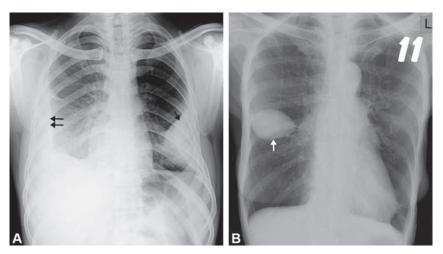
Chest X-ray shows pleural effusion on right side (arrows)
